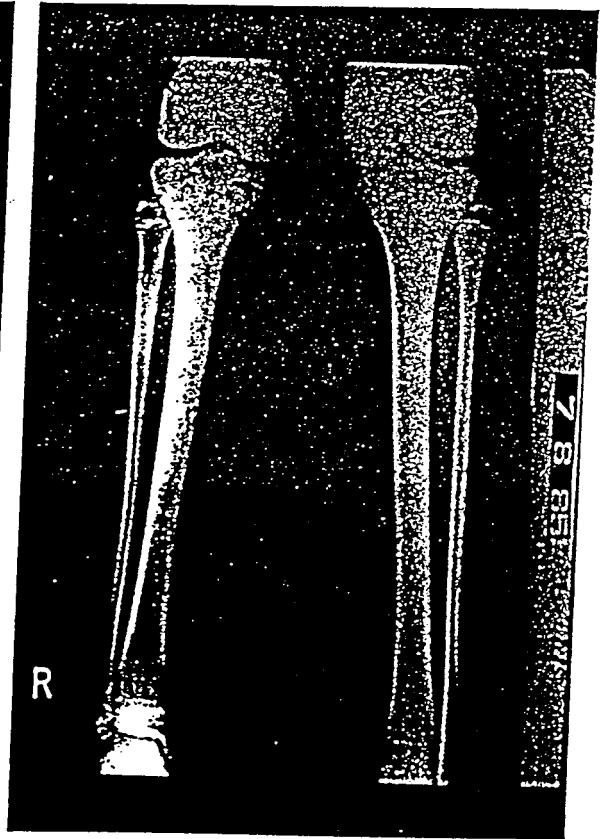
X-ray (7 Aug. 1985), after two years and ten months of Ukrain therapy.
